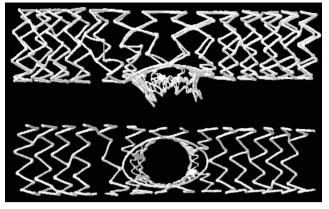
Microcomputed tomographic image of a deployed Petal dedicated bifurcation stent viewed from the side (upper panel) and from inside the stent looking towards the petal elements (lower panel).
